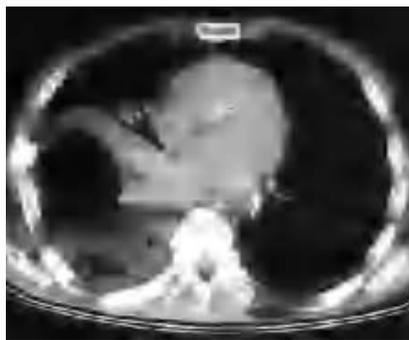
Computed tomography scan of the thorax showing cavitation with an air-fluid level in the upper right lobe.
